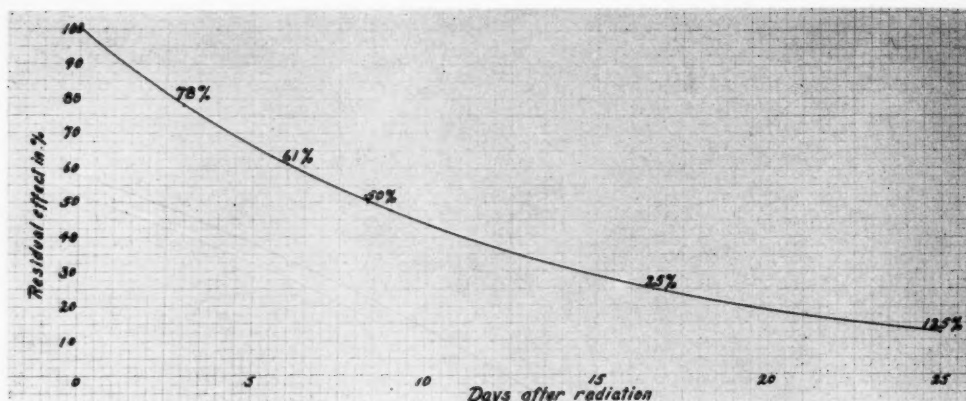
Residual effect of X-rays at 200 K.V. with 0.5 mm. Cu filter, 0.16 Å. from the time of radiation over a period of 25 days (10) as observed from the skin reaction.
